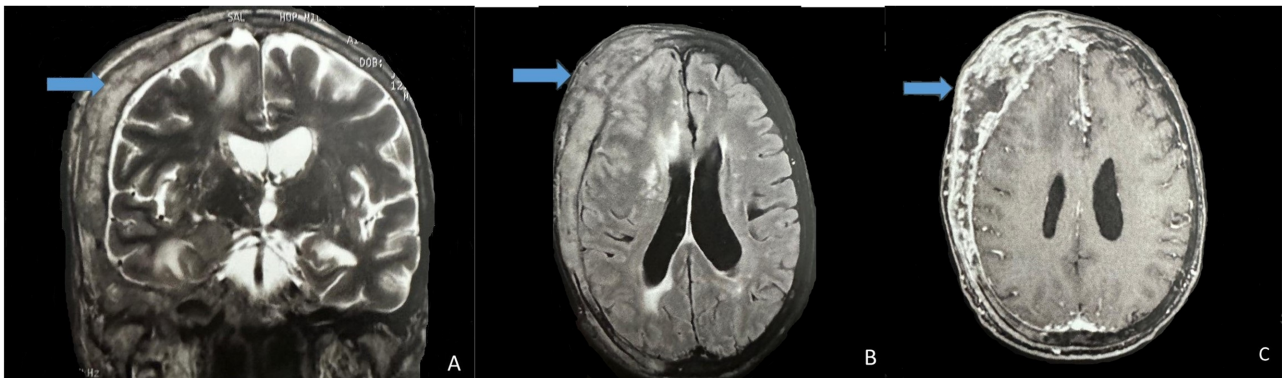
Coronal T2-weighted spin echo (A), axial Flair-weighted spin echo images (B) and postcontrast axial images (C) demonstrating destructive lesion of the diploic mass, leptomeningeal thickening and contrast enhancement, and extension of the lesion to subcutaneous tissue.
